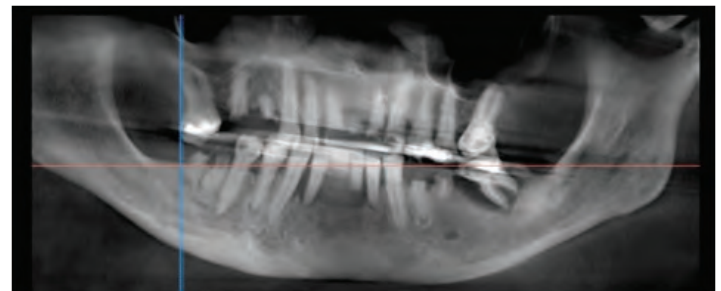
Panoramic Rendering from Digital CBCT
